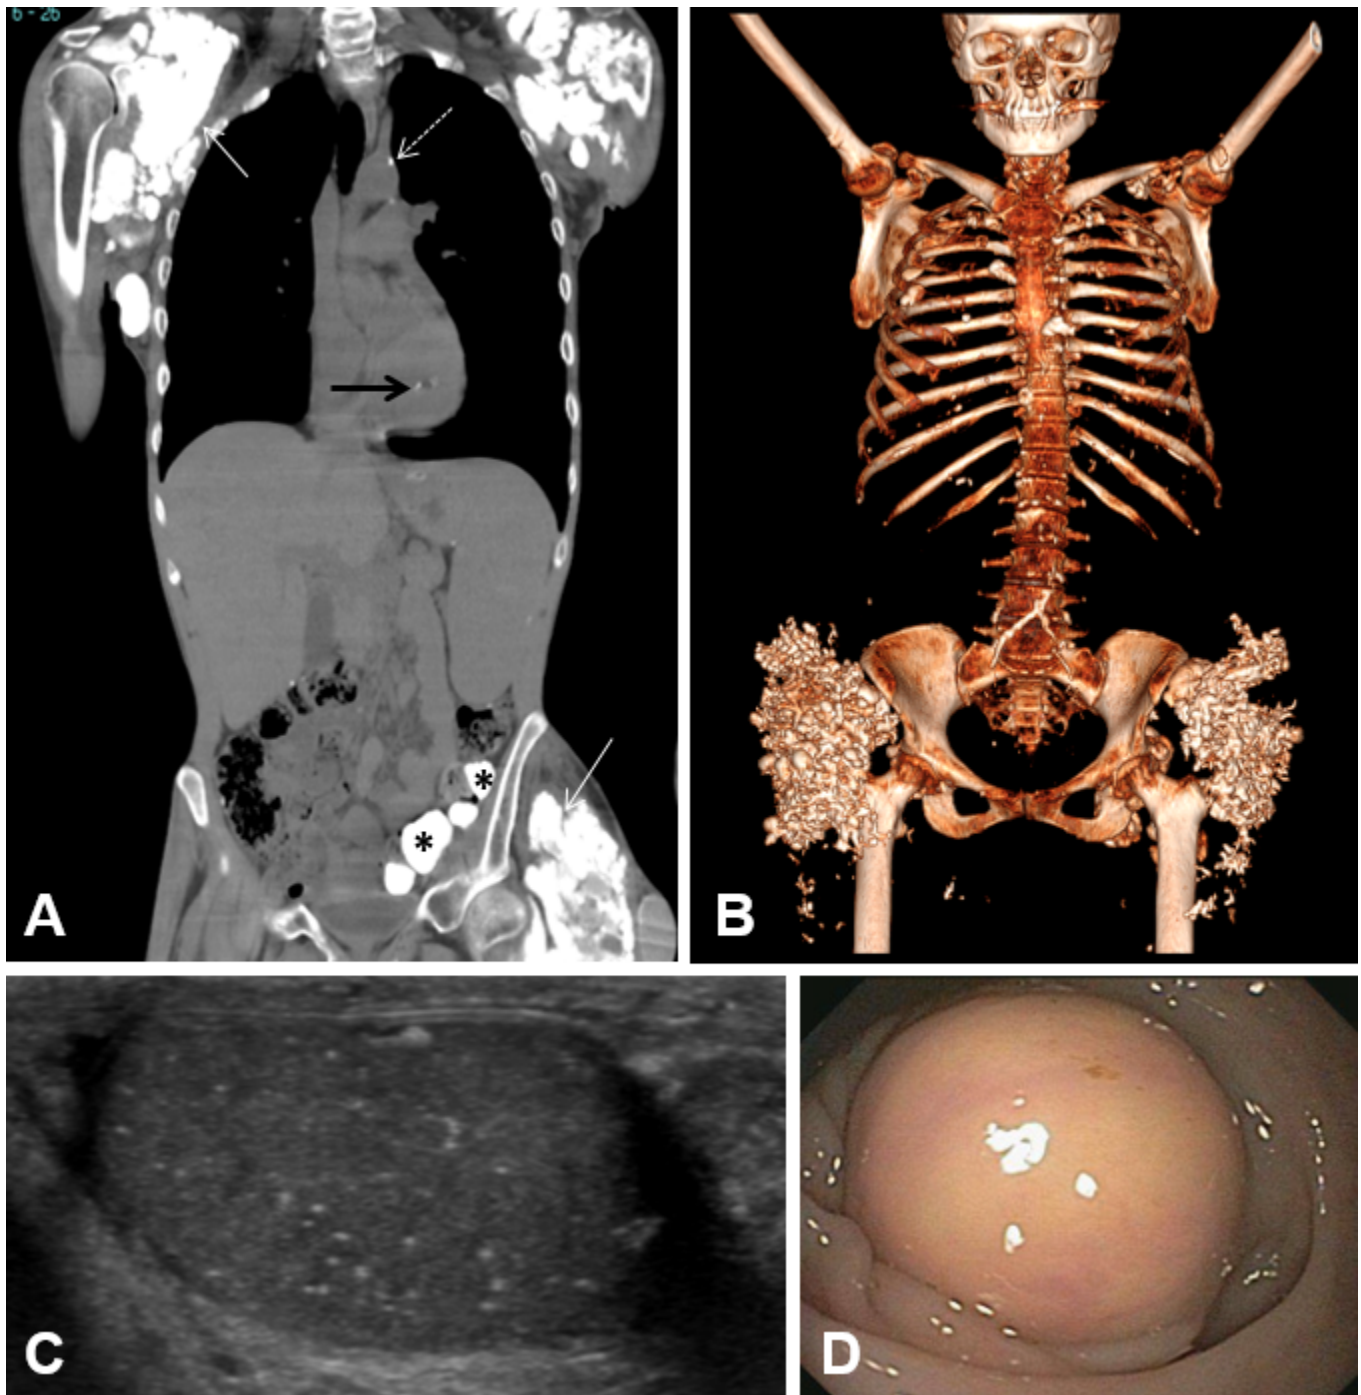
A. Computed tomography (CT) scan showing calcifications in an adult with HFTC including shoulder and hip soft tissue calcifications (white arrows), aortic calcification (dashed arrow), papillary muscle calcification (black arrow), and submucosal gut calcifications (asterisks)
